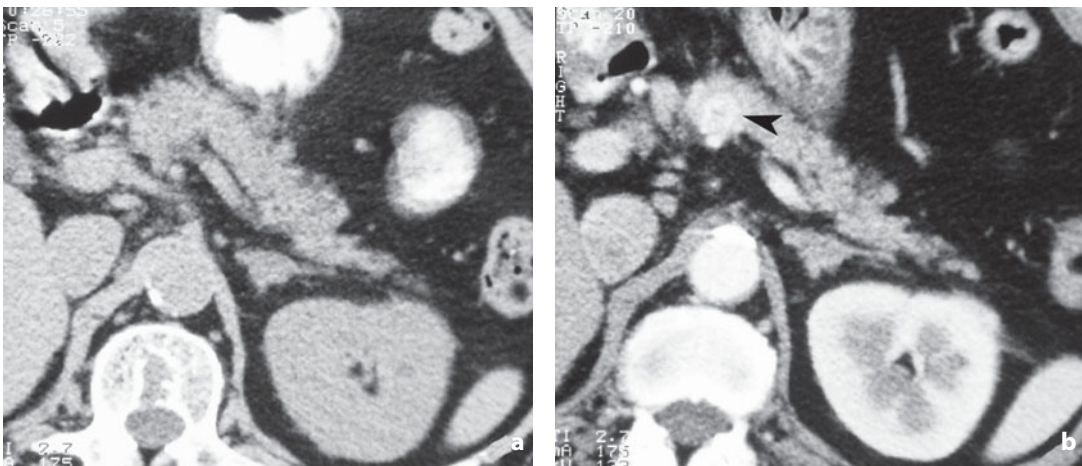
Computed tomography. Pancreatic metastasis following right nephrectomy. Axial nonenhanced (*a*) and enhanced (*b*) images in the arterial phase. The latter shows a hypervascular nodule at the level of the isthmus (*arrowhead*)
